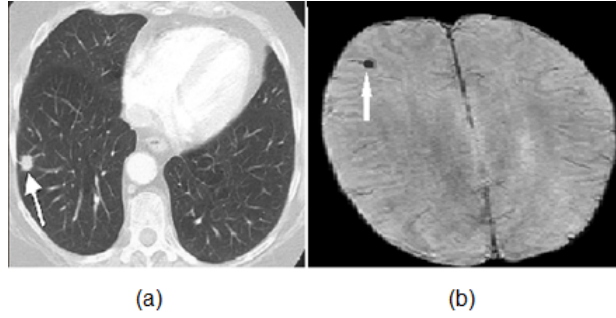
(a) In a lung CT slice of chest, the lung nodule is pointed out by a white array. The heart, spinal cord and the other organs are shown in the center of the image where the lungs are separated. (b) In a brain MR image a CMB is indicated by an array. The intensity difference of the CMB and vessels as dark structures in MR and the lung nodule and vessels as white structures in CT can be seen in these images.
